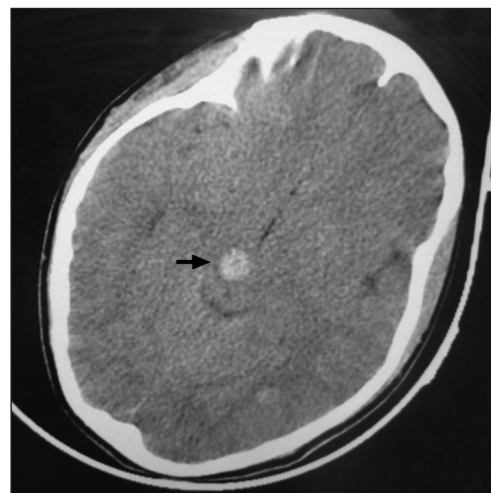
Noncontrast computed tomography scan of the head showing blood in the ventral midbrain on the right side.
